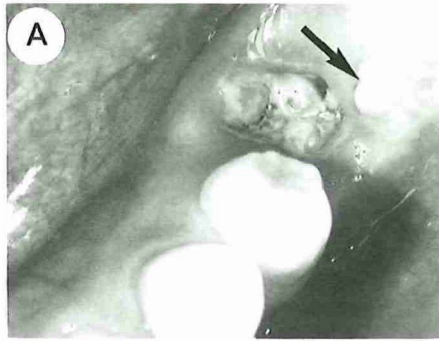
A Clinical view of the mandible of a 14-year-old girl with secondary retention of the left first permanent molar. Note that only the distal surface of the impacted second molar is visible (arrow). B Orthopantomogram of the same patient showing secondary retention of the first molar and horizontal impaction of the second mandibular molar on the left side.
